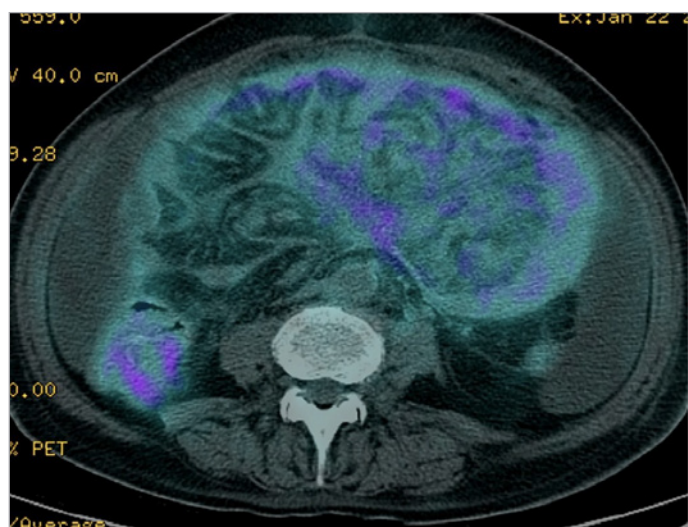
Abdominal involvement by PET-CT in Erdheim-Chester disease.
